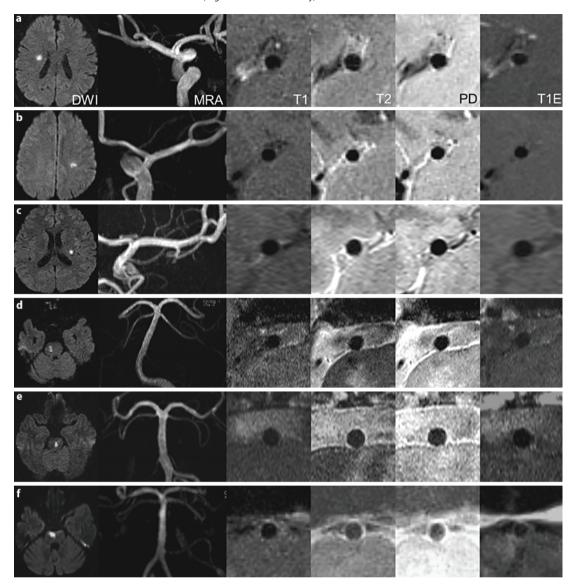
Imaging findings of 6 patients without branch atheromatous plaque in the MCA or BA. a-c Patients 1–3: DW images showing a focal high signal intensity lesion in the right corona radiata, left corona radiate, and left basal ganglia, and MRA showing a normal MCA. d-f Patients 7–9: DW image showing a focal isolated lesion in the right pons, left pons, and right pons extending to the basal surface, and an MRA showing no significant stenosis in the BA. All HR-MRI sequence, T1, T2, PD, and T1E images demonstrating normal vessel walls without enhancement.
